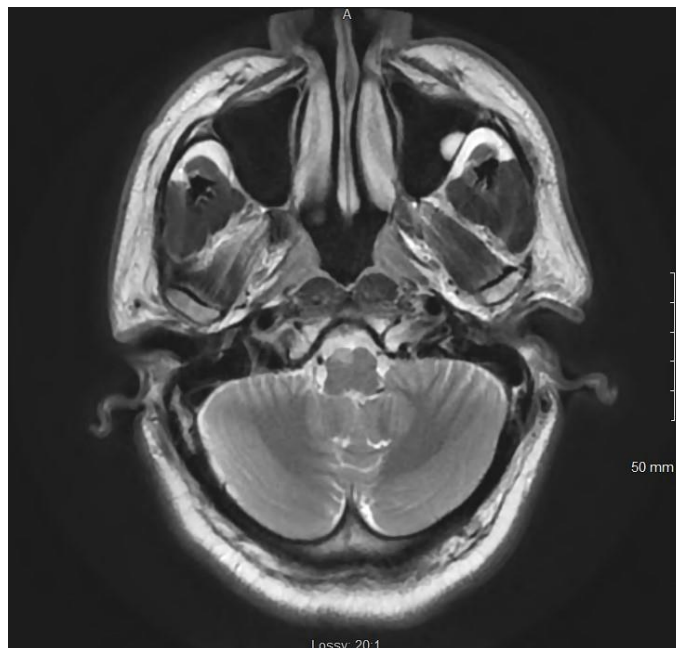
DWI MRI Brain, image obtained on admission, showing classic area of infarct involving the right medulla, extending to the corticospinal tract. Replicated with permission from the Department of Radiology, Saint Vincent Hospital, Worcester, MA
